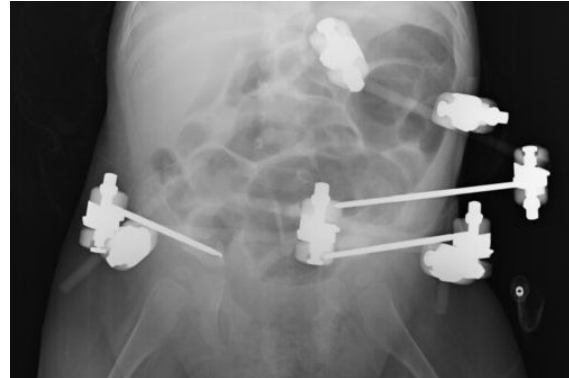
Anteroposterior X-ray graphy on the 15th day.
